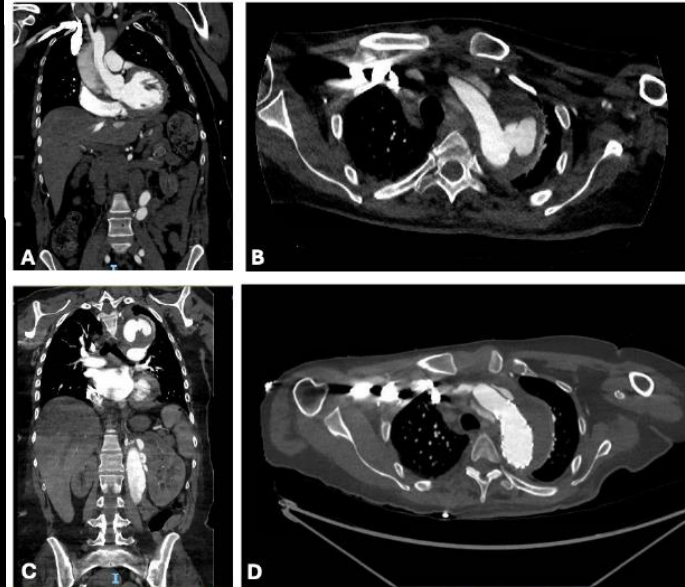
Computed Tomography Angiography (CTA) of (A) Acute type A aortic dissection (ATAAD) on initial presentation with right common carotid artery occlusion. (B & C) Pseudoaneurysm of the descending thoracic aorta distal to the ATAAD repair and proximal to the previous thoracoabdominal repair. (D) Exclusion of the pseudoaneurysm after successful thoracic endovascular aortic repair (Gore cTAG 34 mm X 34 mm X 200 mm graft)
